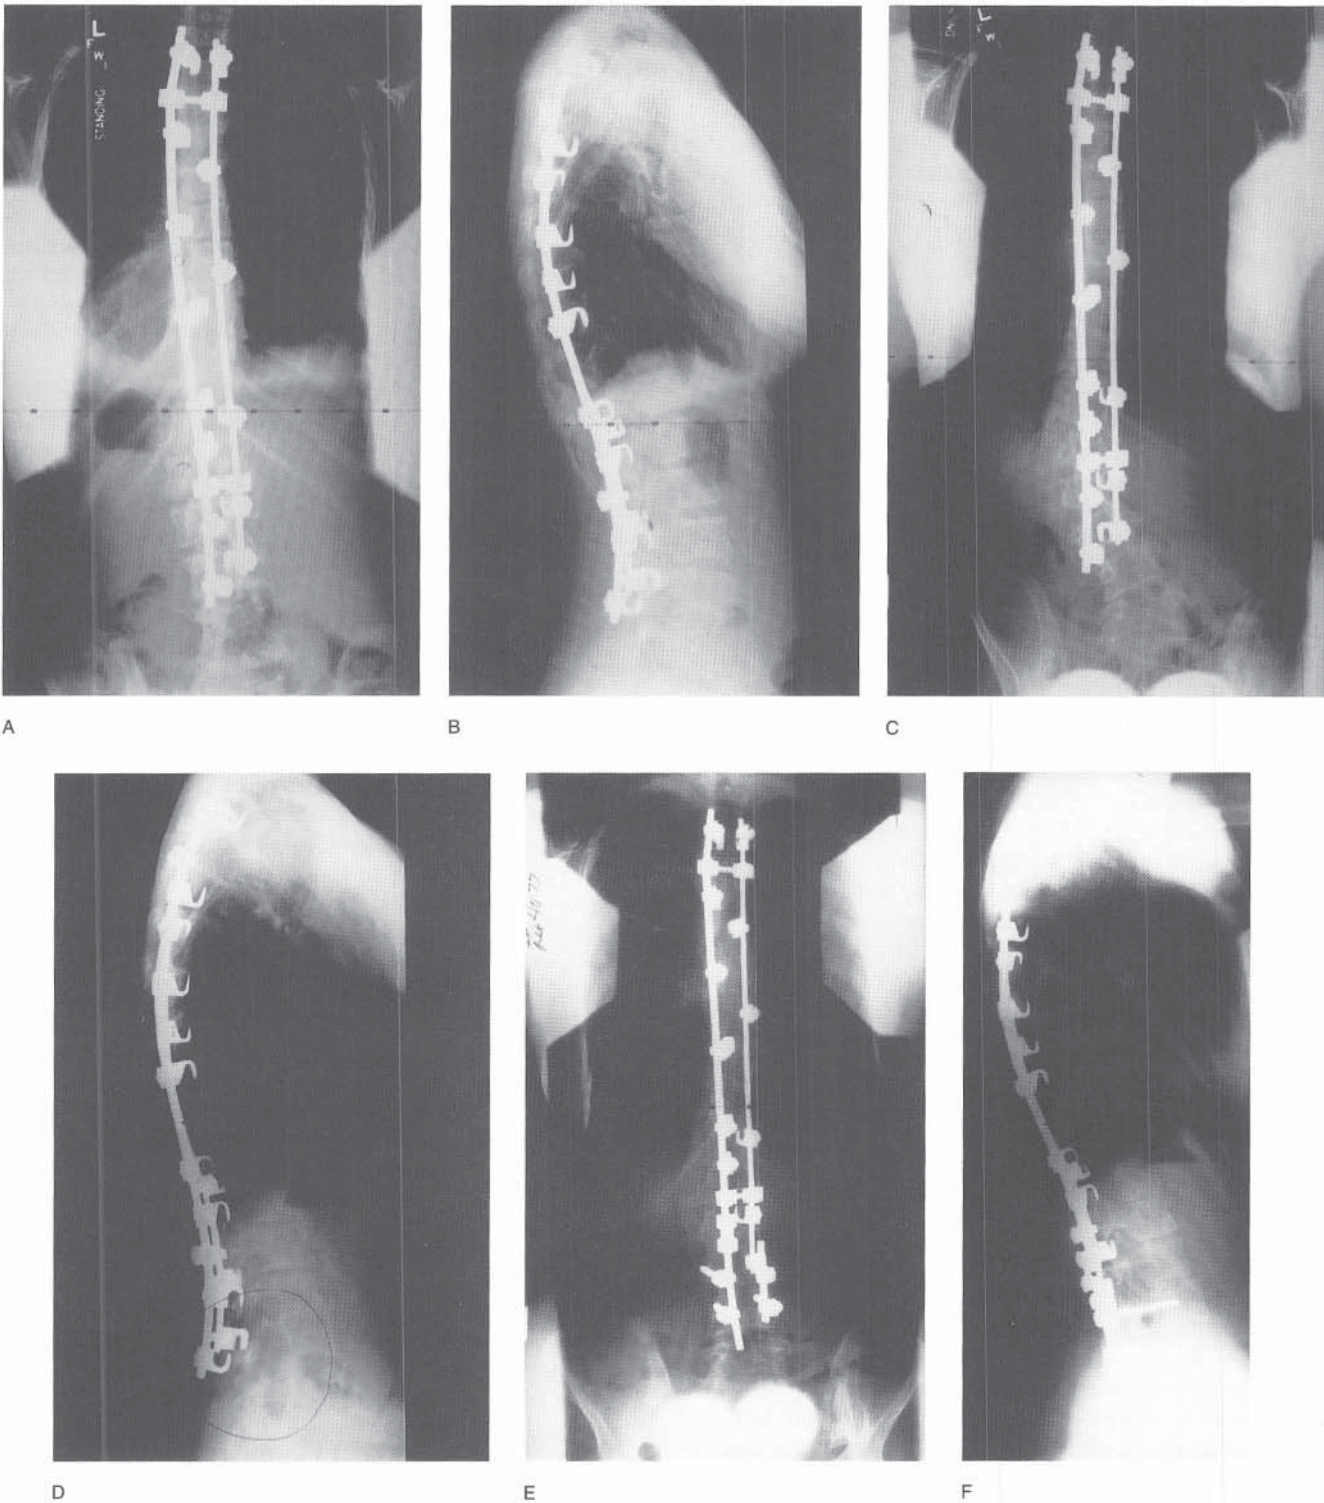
The patient whose clinical and radiographic findings are shown in Figure 11-76 underwent posterior instrumentation and fusion. Excellent correction was achieved (A, B). Five months later, she noticed worsening balance in the lower spine. Radiographs showed that the inferior portion of the instrumentation had dislodged (C, D). The patient was decompensated to the left and had lost correction of the lumbar curve. The lower segment was revised using pedicle screws, rod extensions, and rod cross-links. Three years later her balance remained improved and she was asymptomatic (E, F).
